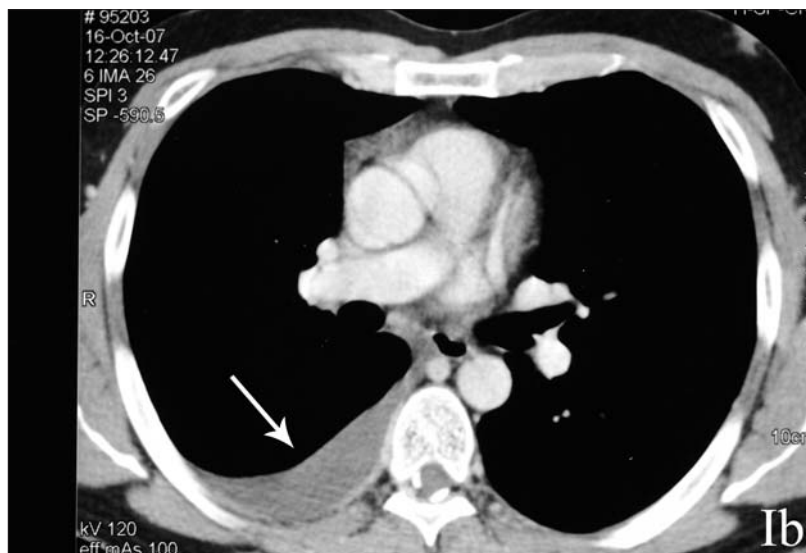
CT scan showing the presence of a pleural effusion on the right hemithorax (in 2007).
